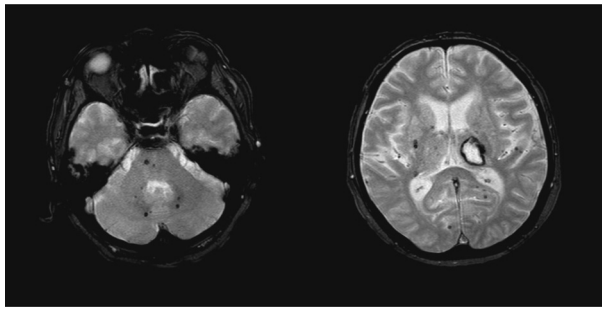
Cerebral microbleeds in patients with intracerebral hemorrhage. Gradient-echo T2*-weighted magnetic resonance imaging is used to detect hemosiderin deposits; these manifest as small spots with attenuated signals and are referred to as cerebral microbleeds in patients with stroke.
